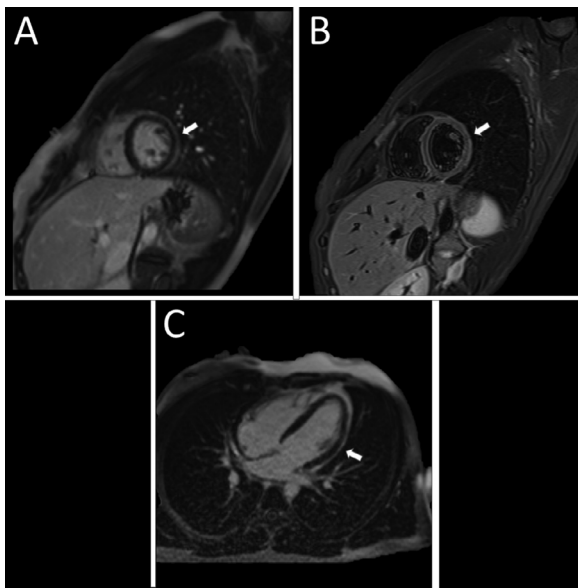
Patient's cardiac magnetic resonance imaging scan; white arrows show subepicardial delayed gadolinium enhancement of the anterior and lateral wall of the left ventricle.
